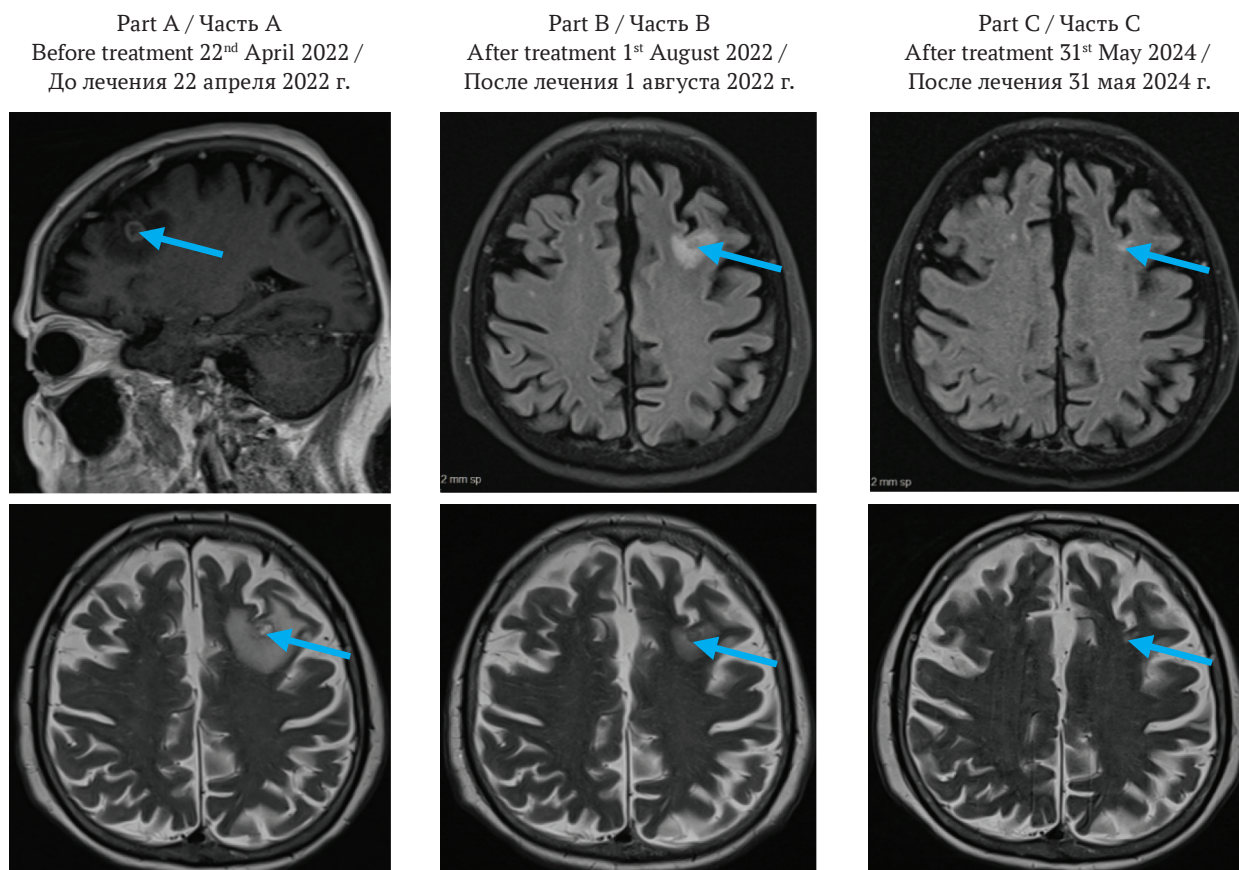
Brain magnetic resonance imaging.
